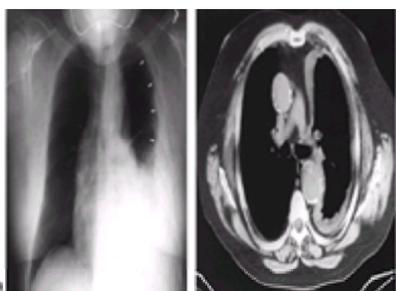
A: A chest radiograph reveals a blunted costophrenic angle with a lobular configuration (*white arrowheads*) along the lateral pleural surface. This is atypical for a simple transudative pleural effusion, which would exhibit a smooth interface between the lung and pleura and not surround the entire lung. The chest radiographic appearance is very suggestive of a mesothelioma, which was confirmed on chest CT. B: A single image from a chest CT scan shows an encased left lung with associated contraction of the hemithorax.
